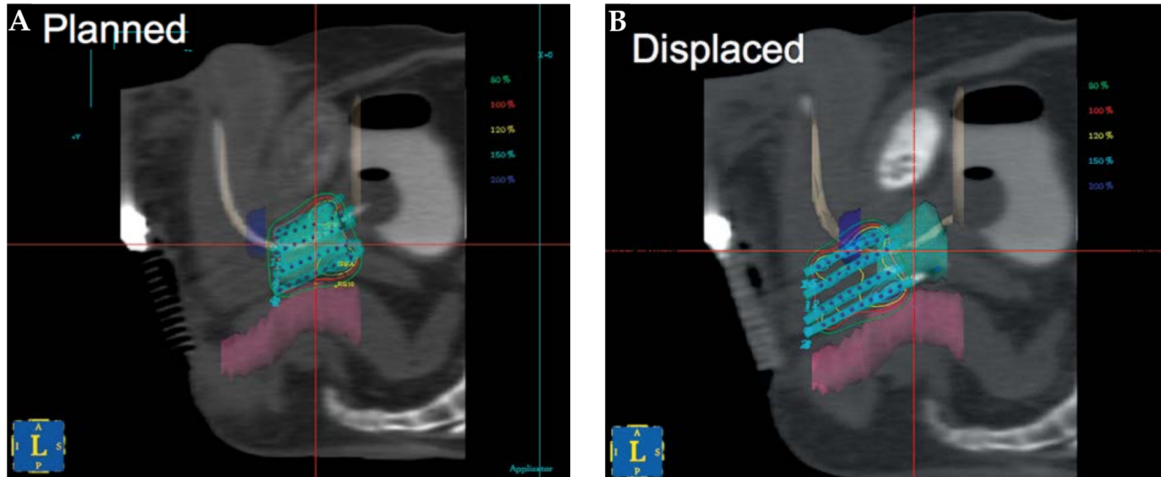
A comparison between two CT-based plans for prostate HDR-BT: one with a highly conformal dose delivery (A); the other with target underdosing and urethra overdosing due to unspecified inferior catheter displacement (B). (50).
